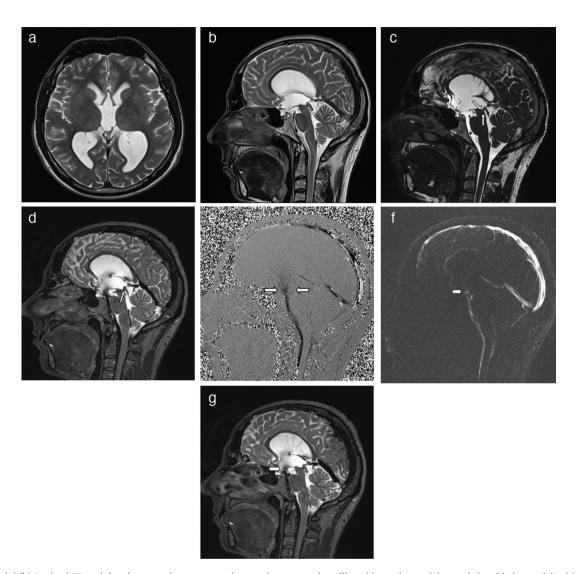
(a) Axial (b) Sagittal T2-weighted magnetic resonance image demonstrating dilated lateral ventricles and the third ventricle. (c) Sagittal threedimensional (3D) constructive interference in steady state (d) Sagittal three-dimensional driven equilibrium (3D-DRIVE) sequence demonstrating aqueductal stenosis with a dilated ventricular system. The vascular structure causing aqueductal stenosis is indicated by an arrow. (e) Sagittal phasecontrast image (f) Sagittal magnitude image (g) Sagittal 3D-DRIVE revealed a defect at the base of the third ventricle, and a significant flow signal consistent with spontaneous third ventriculostomy was observed. Note that no flow signal was detected at the aqueduct cerebri level.
